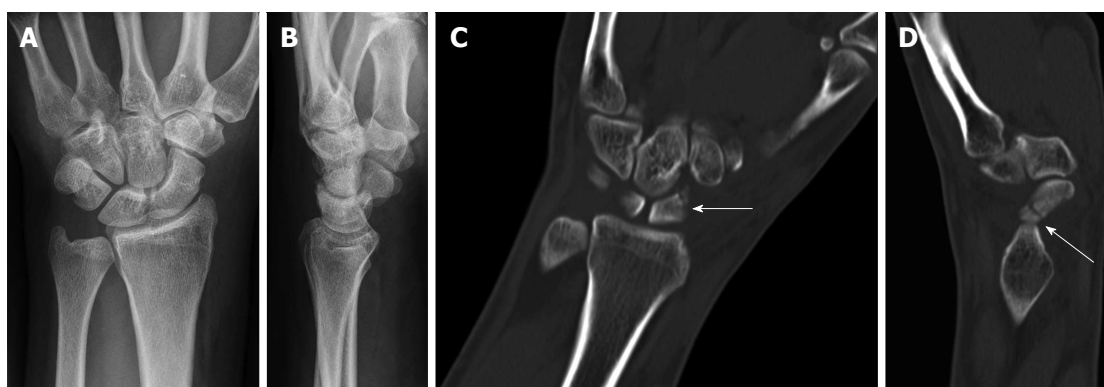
Non-dislocated fissural fracture of the scaphoid that had not been detected by initial conventional radiography (A and B). Cross-sectional multidetector computed tomography clearly depicted the oblique fissural fracture line in the middle third of the scaphoid with coronal (C) and sagittal (D) reformation on the same day.
